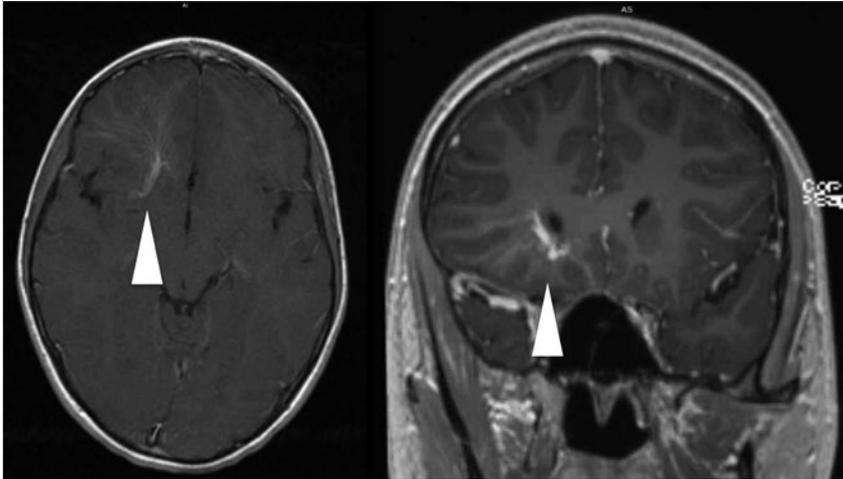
Magnetic resonance images of a typical developmental venous anomaly (DVA), with an axial (left) and coronal (right) T1 postgadolinium sequence. The *arrowhead* in each image notes the classic DVA base with a “Medusa head.”
